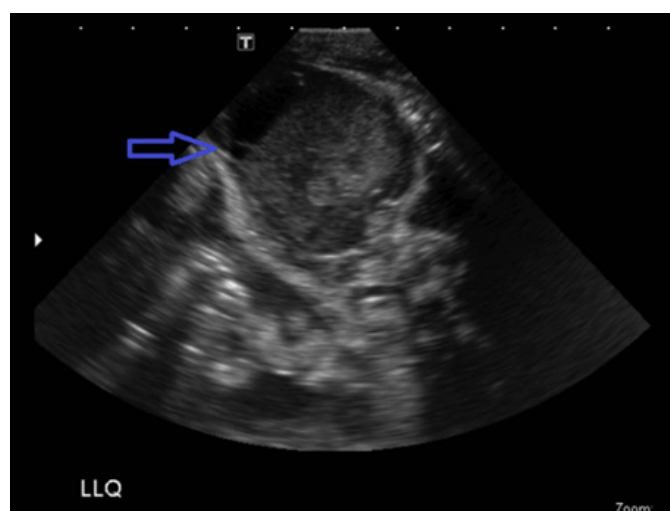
Ultrasound of left lower quadrant showed a heterogeneous mass in the left abdomen medial to the spleen and anterior to the left kidney measuring approximately 4.8x3.6x4.9 cm.
